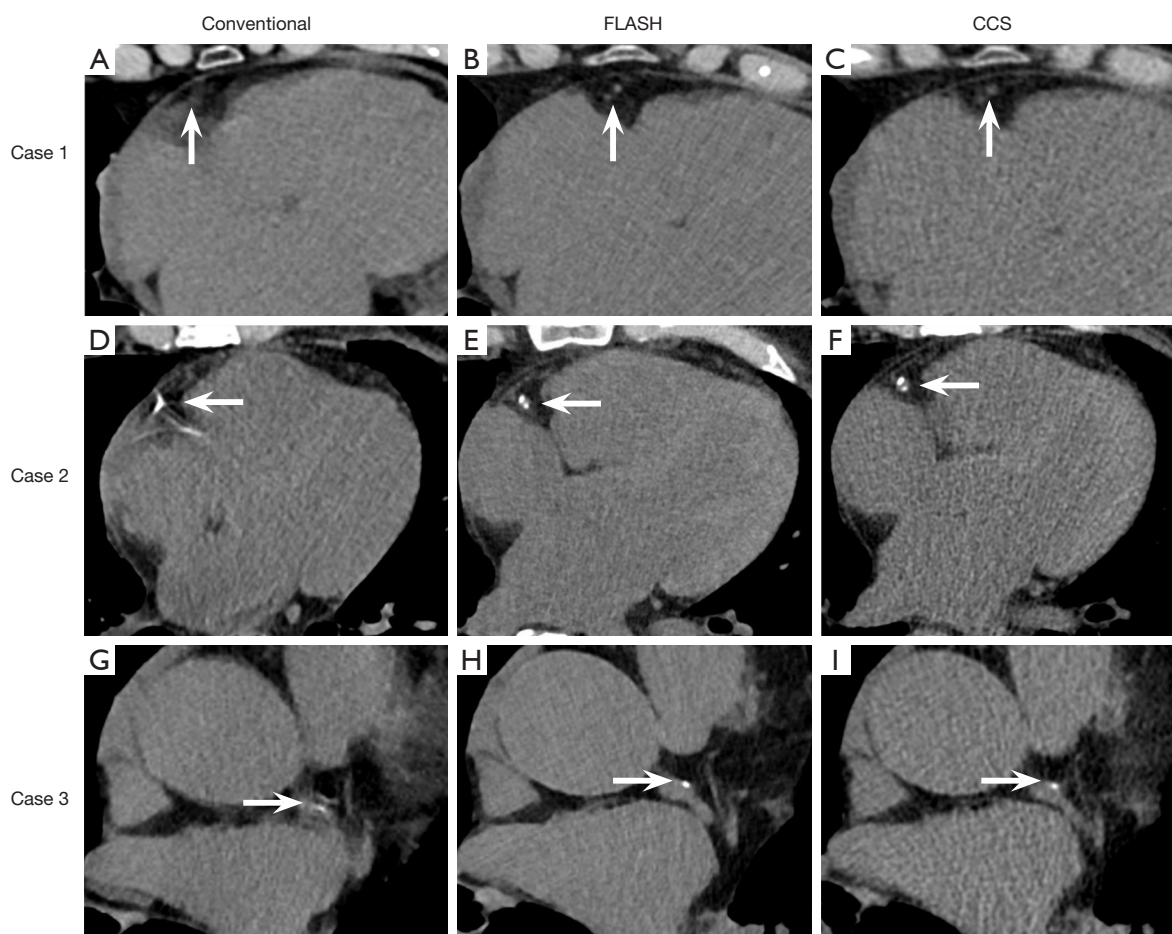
Representative images of coronary image quality from three scanning methods. To visually compare coronary image quality among three CT examinations, namely, chest CT (FLASH), chest CT (conventional), and CCS, we identified eligible patients who underwent all three scans within three months using the hospital information system. A limited number of patients met the criteria, and three cases with representative coronary artery segments (arrows) are presented in the figure above. (A-C) Case 1: no calcified plaques present. (D-F) Case 2: presence of calcium plaques. (G-I) Case 3: a calcified plaque was detected on chest CT (FLASH) (H) and CCS (I) but was missed by chest CT (conventional) (G). CT, computed tomography; CCS, coronary calcium scan.
